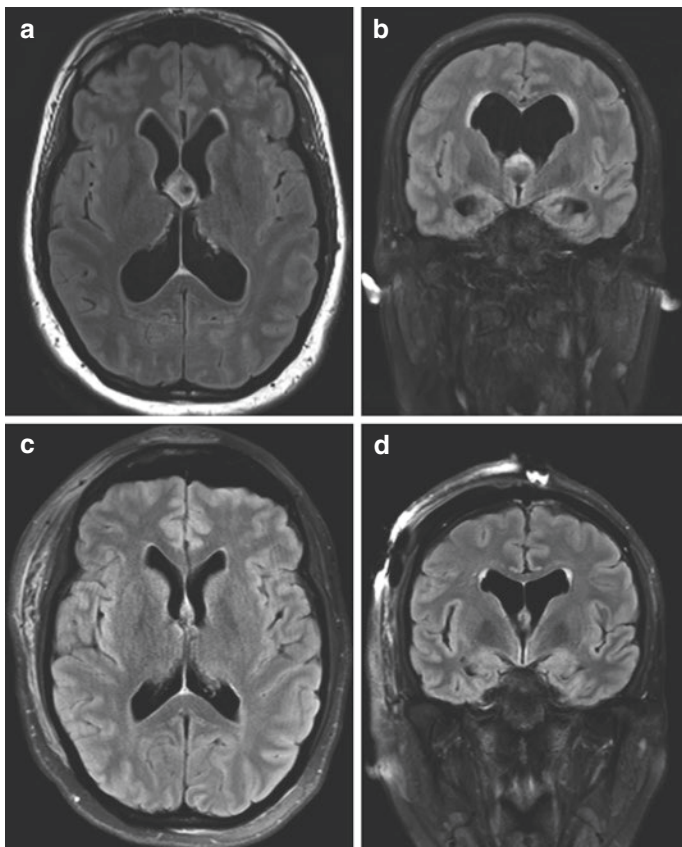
Case 3 Imaging. (a, b) Preoperative axial and coronal FLAIR MRIs demonstrate an intraventricular mass centered at the foramina of Monro, consistent with a colloid cyst. Note the dilated ventricular system, a sign of obstructive hydrocephalus. (c, d) Postoperative axial and coronal FLAIR MRIs demonstrate gross total resection with resolution of the hydrocephalus
